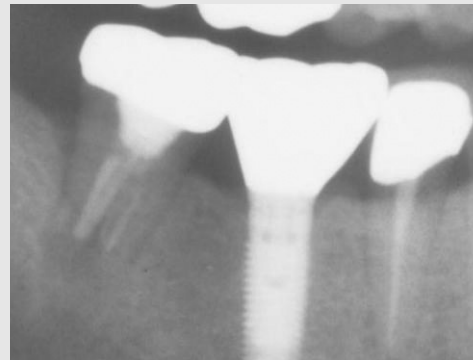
Doubtful case: post-op periapical view.
